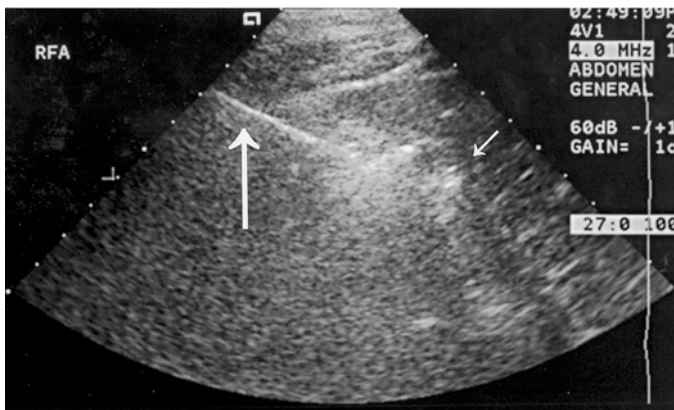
Ultrasound guided radio frequency ablation. Probe (bold arrow) has been inserted into center of tumor. Microbubbles are beginning to form around probe electrodes (thin arrows).
